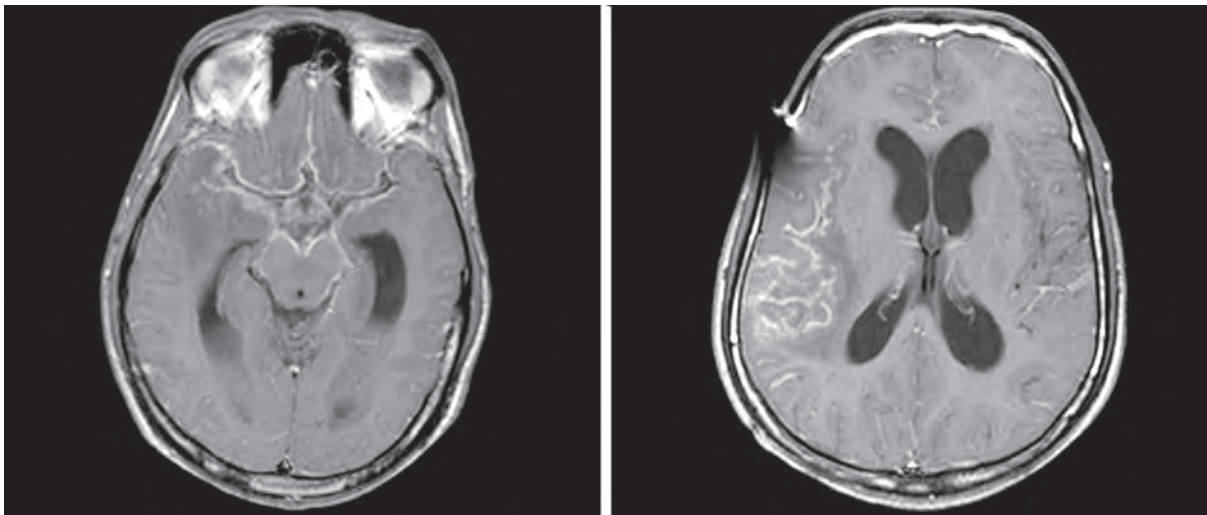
MRI of the brain showing meningitis with hydrocephalus
